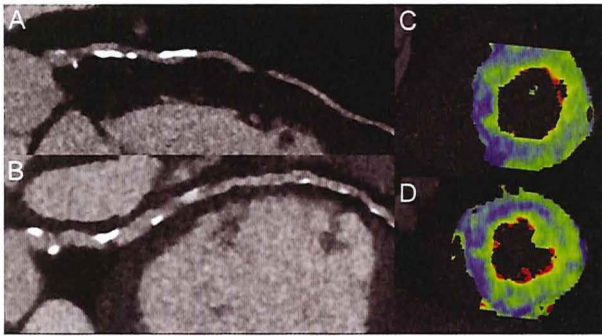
70-year-old man with hypertension and progressive dyspnea. Calcium score was 1580 Agatston. CCTA demonstrates diffuse atherosclerotic disease in the left anterior descending, LAD, (A) coronary artery and in the left circumflex, LCX (B) coronary artery. A stack artefact is visible in the mid-distal LAD coronary artery. Short-axis color-coded dynamic CT perfusion images acquired during the infusion of adenosine show a diffused reduced myocardial perfusion in the anterior, septal and inferior myocardial wall (blue areas) in a left dominant coronary system. Both LAD and LCX lesions were determined to be hemodynamically significant at fractional flow reserve measurements.
